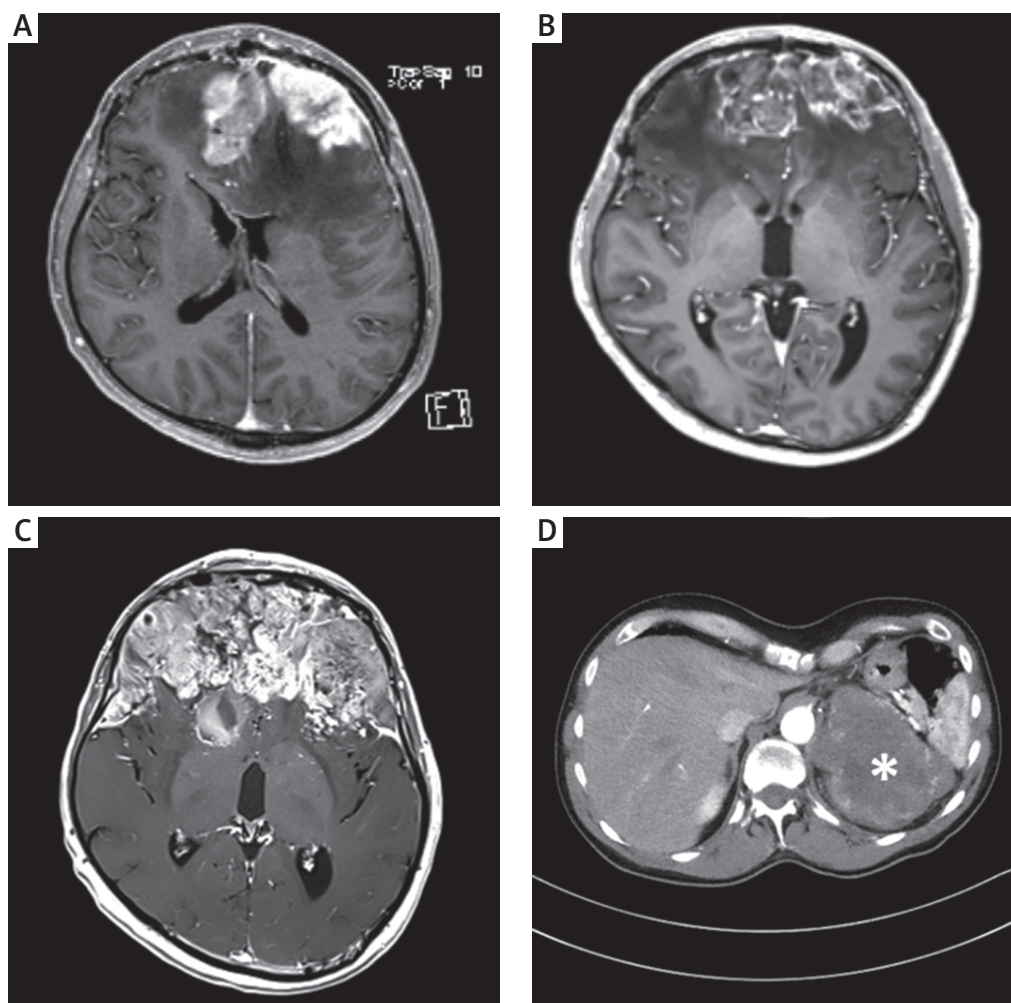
Radiologic findings: first tumour recurrence in the frontal area, October 2015, T1 MRI (A); second tumour recurrence, November 2016, T1 MRI (B); third tumour recurrence, September 2017, T1 MRI (C); tumour of the adrenal gland (asterisk), May 2017, contrast-enhanced CT scan (D).
